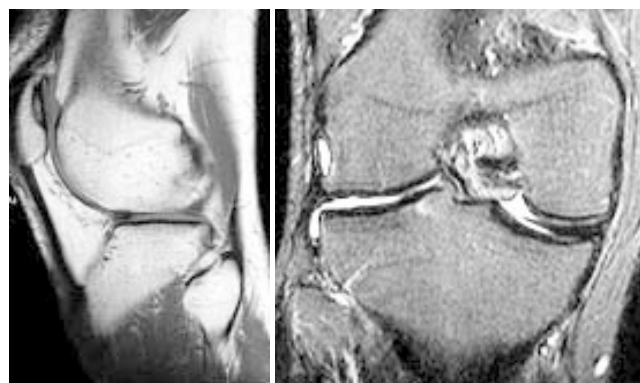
Preoperative MRI showing lateral meniscus deficient knee.
